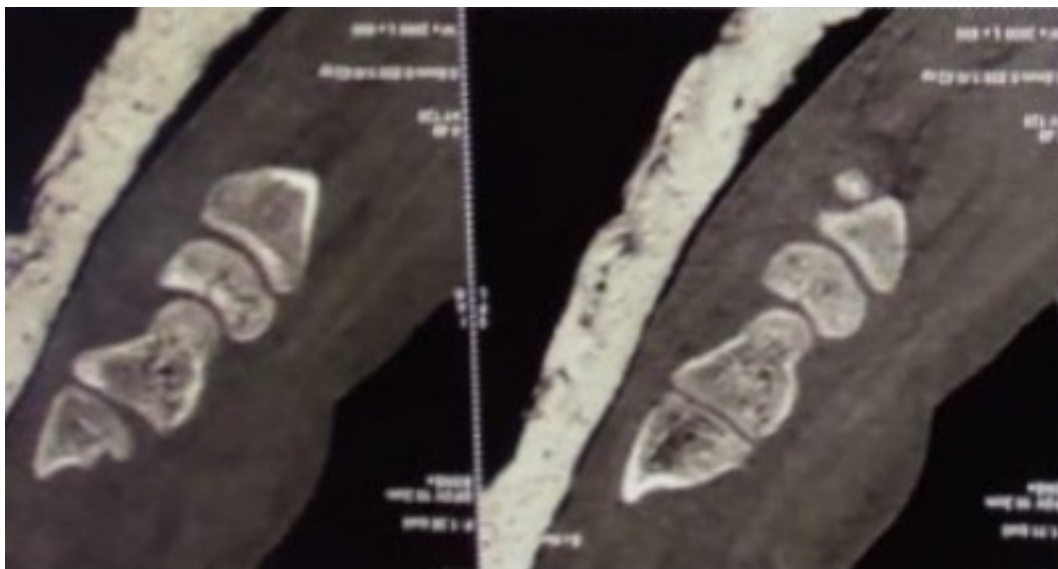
The CT scan showed lunatum fracture after reduction
